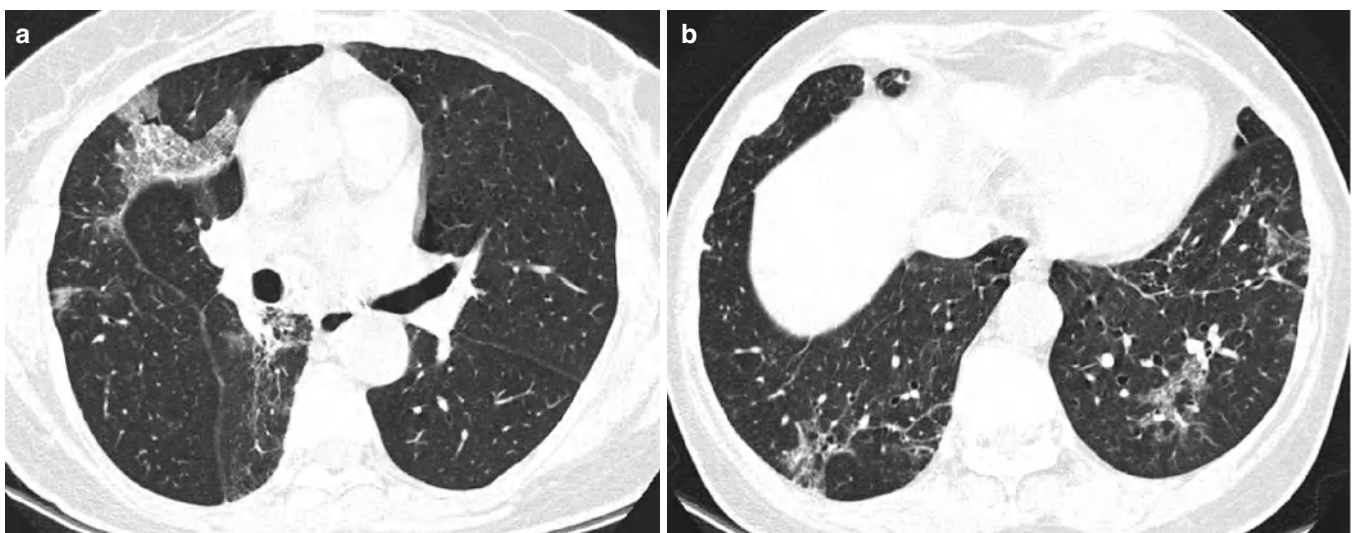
Lymphocytic interstitial pneumonia in a 63-year-old woman with Sjögren's syndrome. (a, b) Lung window of CT scans (2.5-mm section thickness) obtained at levels of bronchus intermedius (a) and liver dome (b), respectively, show patchy areas of ground-glass opacity
